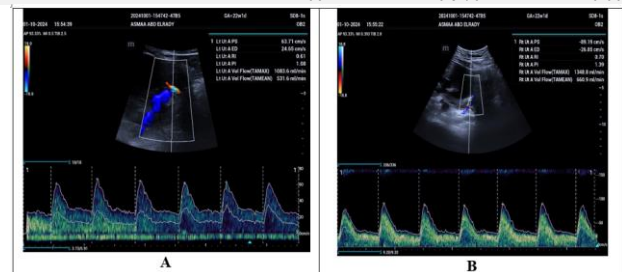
(A): Doppler ultrasound of the left uterine artery at 22 weeks' gestation showing a pulsatility index (PI) of 1.08 and a volume flow of 531.6 ml/min, without evidence of a protodiastolic notch. (B): Doppler ultrasound of the right uterine artery at 22 weeks' gestation with a pulsatility index (PI) of 1.39, end-diastolic velocity of -26.85 cm/s, resistance index (RI) of 0.70, and a volume flow of 660.9 ml/min, also without a protodiastolic notch
